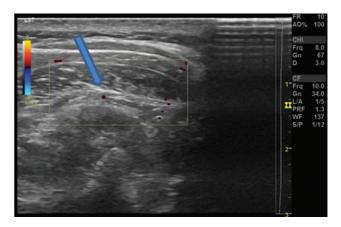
(Case 2)—Ultrasonography image showing occipital artery as an identification point for greater occipital nerve.
